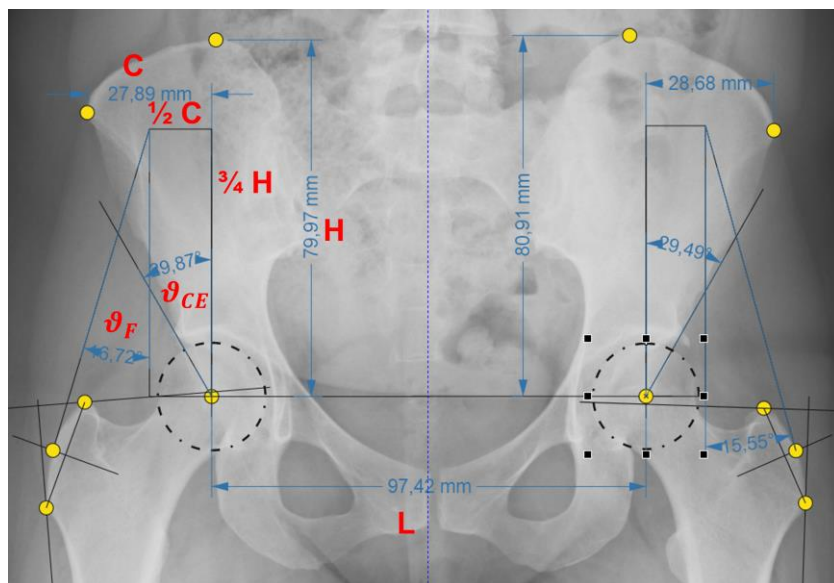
Geometrical evaluation of X-Ray scan according to HIPSTRESS model
